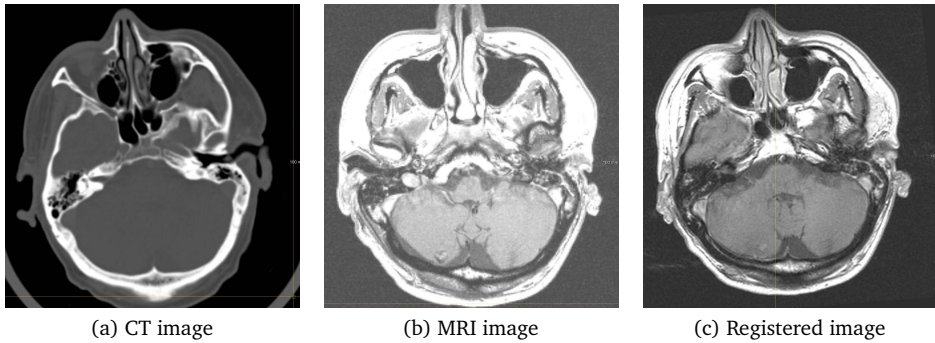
Example of CT-MRI registration for target-volume delineation of brain tumors.
